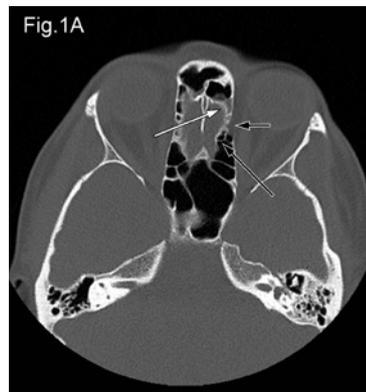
Left lamina Papyracea dehiscence in a 16-year-old female seen on CT of the paranasal sinuses. Bone window demonstrates a left medial orbital wall defect (short black arrow) located anterior to the left basal lamella (long black arrow). These features are compatible with congenital dehiscence. The bulla lamella is indicated with a white arrow. The remainder of the orbit is unremarkable and there is no scan evidence of prior trauma. The remainder of the paranasal sinuses and mastoid air cells are clear.
